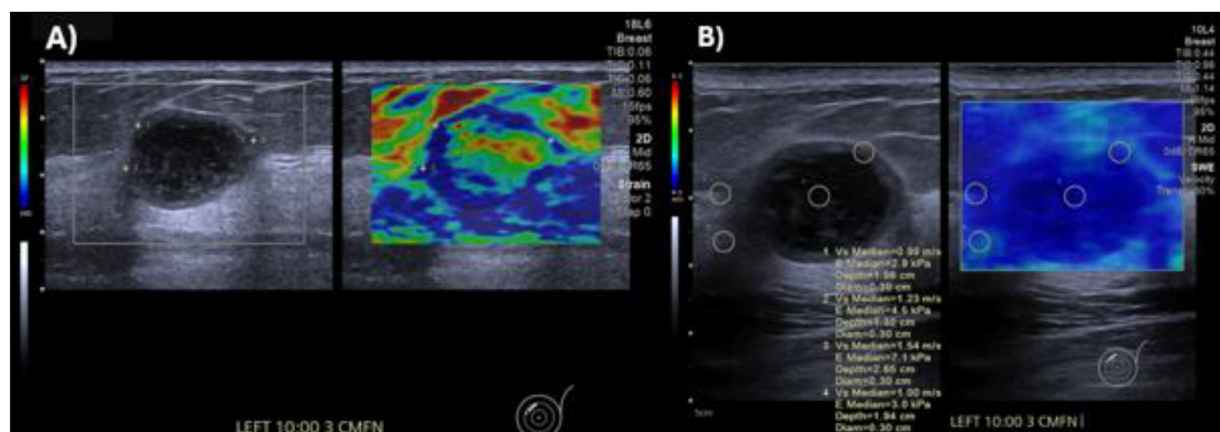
Ultrasound elastography. (A) Strain elastography showed BGR pattern centrally and blue rim peripherally. (B) Shear wave elastography showed normal reading of the thickened wall which was 4.5kPa.
